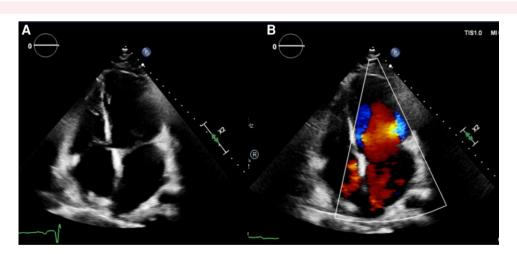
Post-operative echocardiographic images: (A) apical four-chamber view showing successful resection of the fibromuscular membrane, (B) apical four-chamber view with colour Doppler showing laminar flow within the left atrium.
